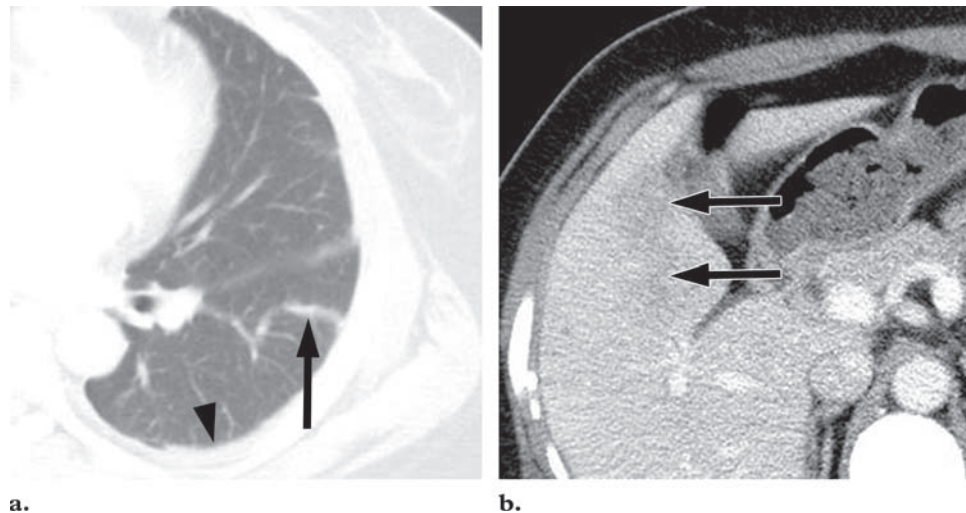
Paragonimiasis involving the lung and liver in a 43-year-old woman. (a) Chest CT scan (lung window) shows a parenchymal band at the subpleural portion (arrow). A coexisting left pleural effusion is also seen (arrowhead). (b) Portal venous phase CT scan shows an ill-defined hypoattenuating area (arrows) at segment V of the liver due to parasites that have migrated toward the center of the liver, causing hemorrhage, necrosis, inflammation, and subsequent fibrosis. CT scans obtained at a lower level demonstrated abdominal wall involvement.
